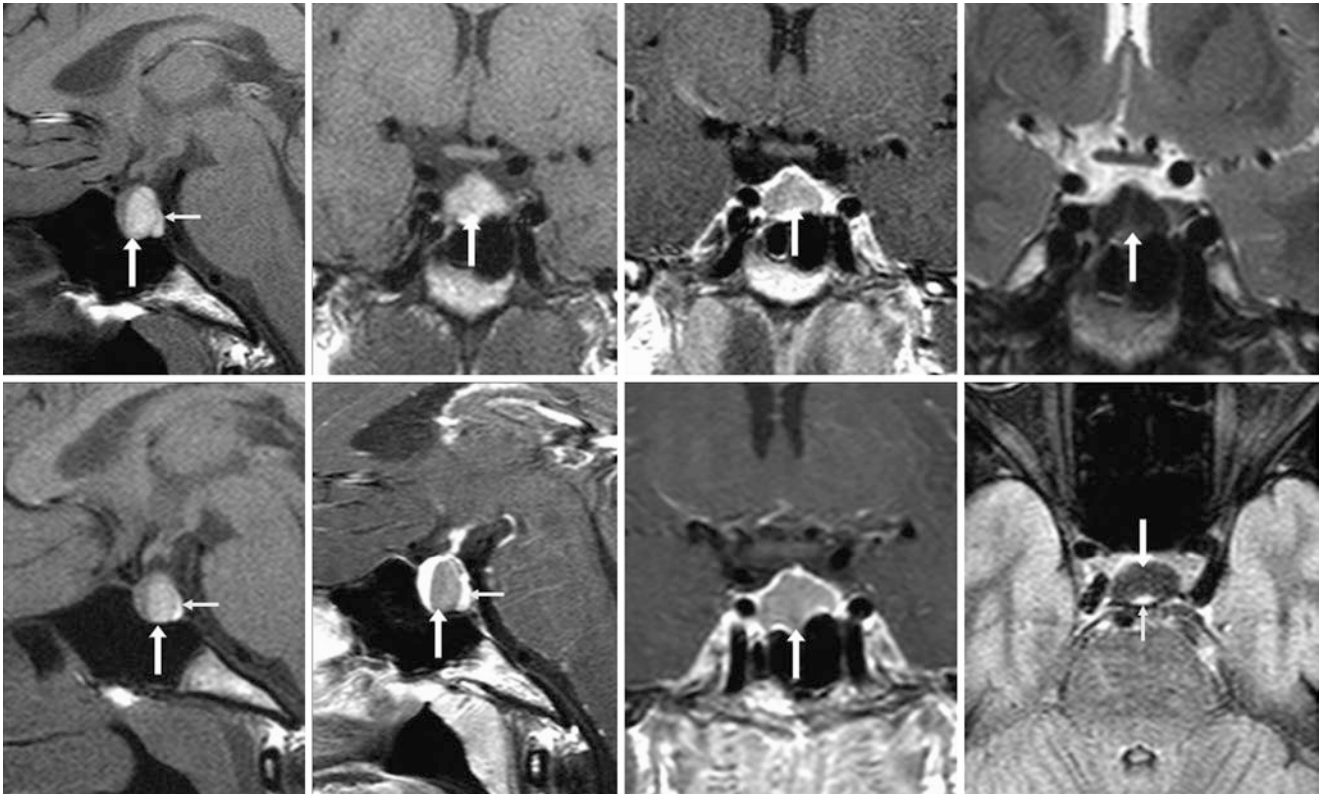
The patient was a 16-year-old female with seizures (no pituitary-related symptoms). A 1.5 T MRI noted a T1-bright 11×9 mm RCC (arrows) on noncontrast sagittal (*top left*) and coronal (*top, left middle*) T1WIs and on postcontrast coronal T1WI (*top, right middle*) and T2WI (*top right*). An MRI 9 years later depicted slight enlargement to 13×10 mm on sagittal precontrast (*bottom left*) and postcontrast
